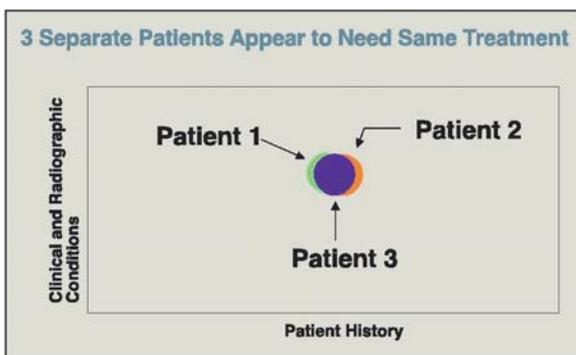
Traditional diagnosis of periodontitis based on clinical and radiographic conditions and patient history without consideration of risk for three patients who all appear to have the same diagnosis and therefore will require the same treatment
